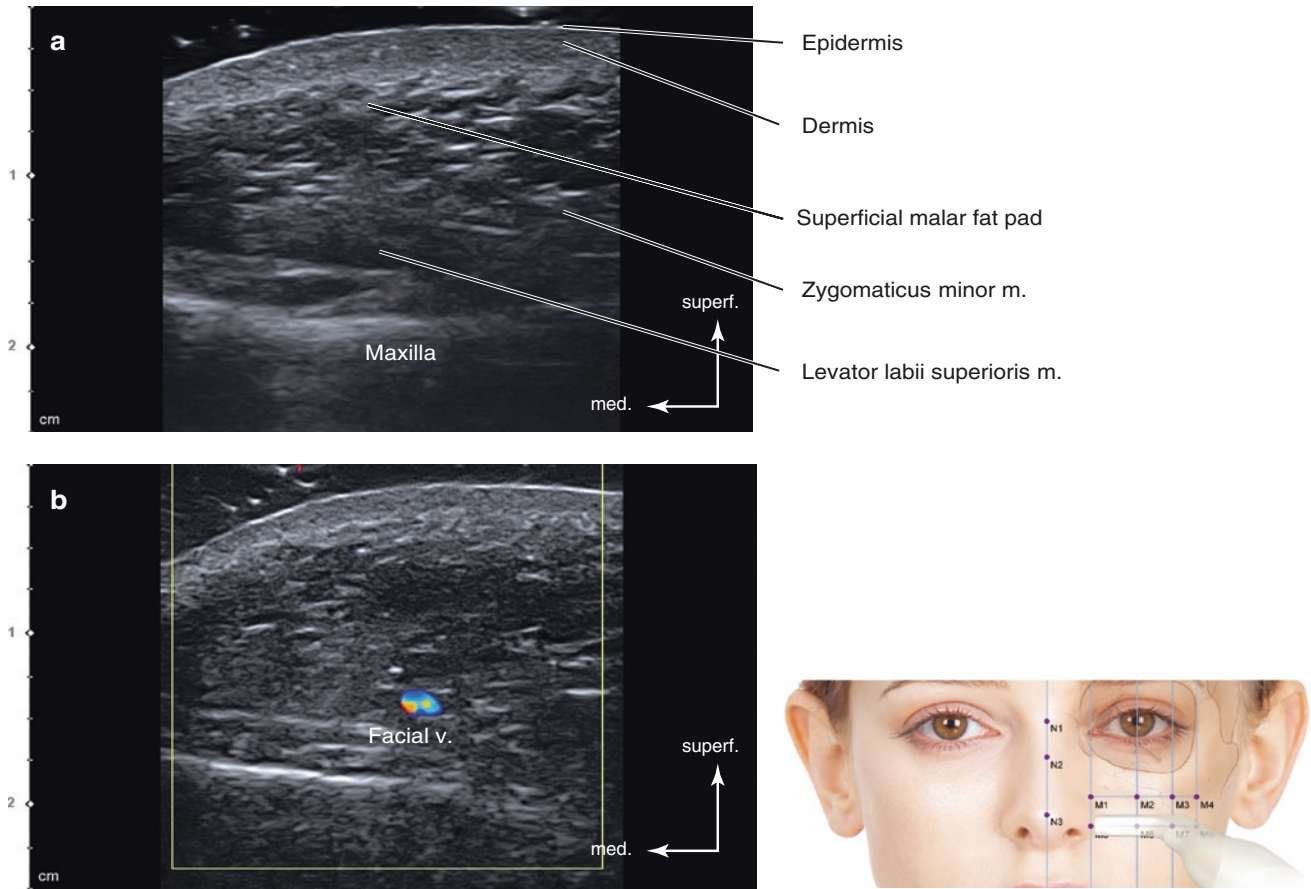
Ultrasonography on the intersection point of TL5 and PL2 (M6). (a) B mode (transverse view, 15 MHz by linear transducer), (b) Doppler mode (transverse view, 15 MHz by linear transducer), (c) B
